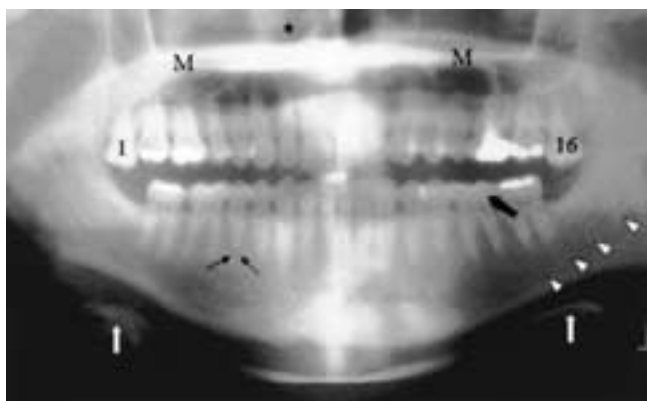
Panoramic radiograph of jaws in an adult with extractions of mandibular third molars. This has caused supereruption (occlusal migration due to lack of contact by the opposing tooth) of teeth numbers 1 and 16. Hyoid bone (*white arrow*). Inferior alveolar canal (*arrowheads*). Dentition (mandibular left second molar) (*bold black arrow*). Right mental foramen (*thin black arrow*). Inferior nasal turbinate (*). Maxillary sinus (M).
